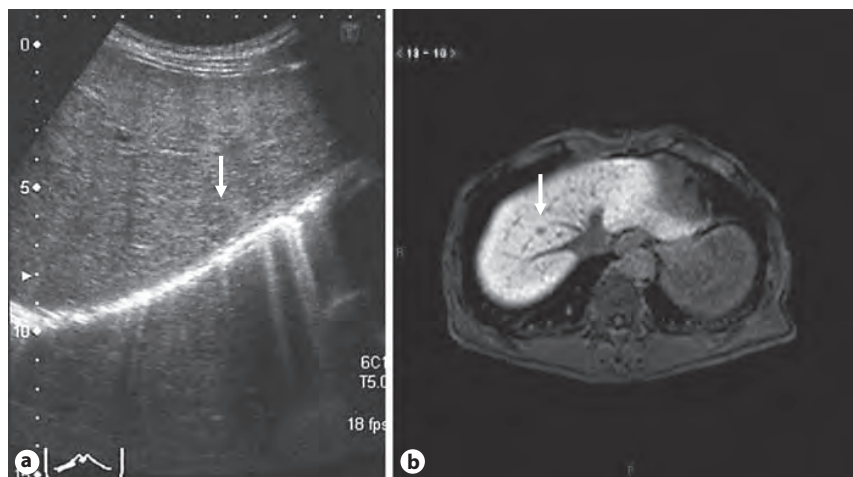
B-mode US imaging; 8-mm hypoechoic nodule in S1 (a). Gd-EOB-DTPA-enhanced MRI revealed a defect in the hepatobiliary phase (b).
